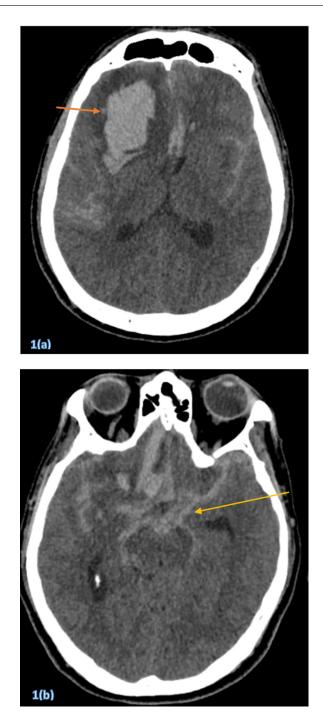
Non-contrast Computed Tomography (CT) of brain showing (a) right intraparenchymal haemorrhage in the right frontal lobe (Orange arrow) with generalized cerebral oedema and (b) diffuse subarachnoid haemorrhage occupying the interpeduncular cistern (Yellow arrow) and bilateral Sylvian fissure. (Color version of the figure is available online)
